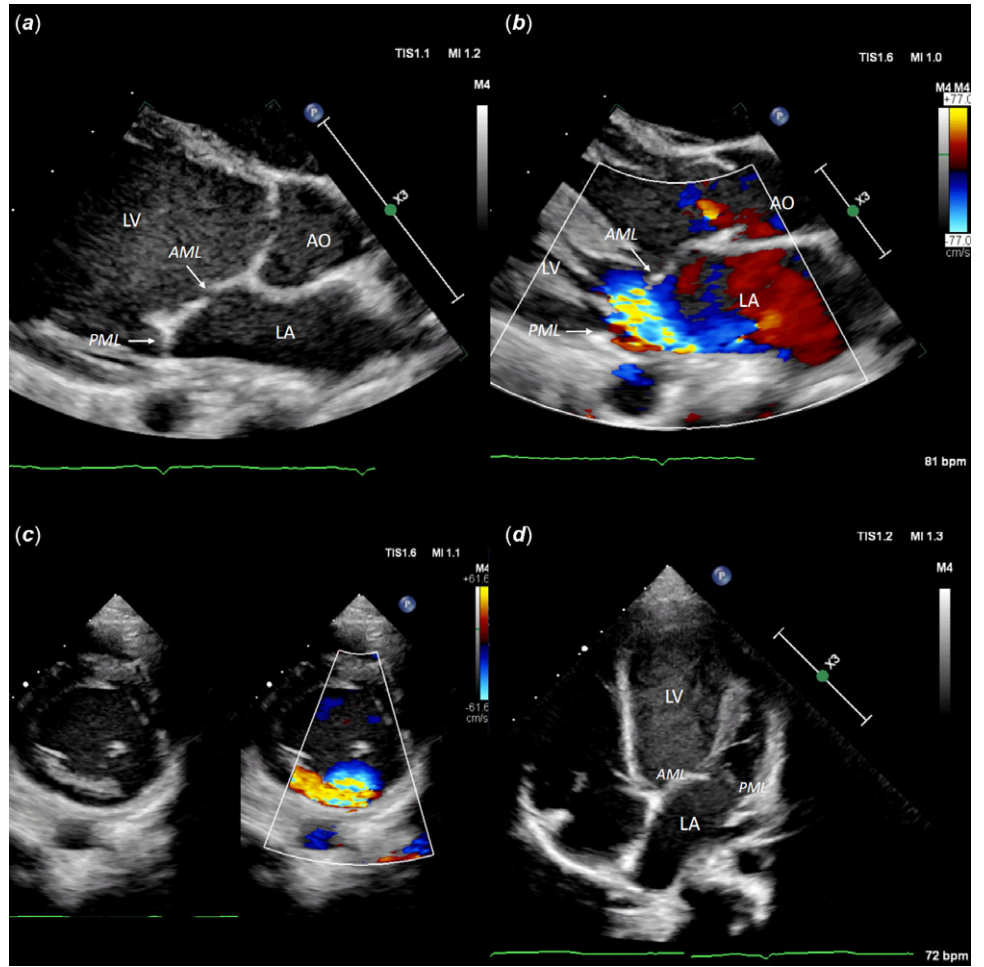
Preoperative echocardiogram of the patient demonstrating inadequate coaptation height of mitral valve with short PML and prolapsed AML. The coloured blood flow shows mitral regurgitation. LV = left ventricle; LA = left atrium; AO = aortic aorta; AML = anterior mitral leaflet; PML = posterior mitral leaflet.
